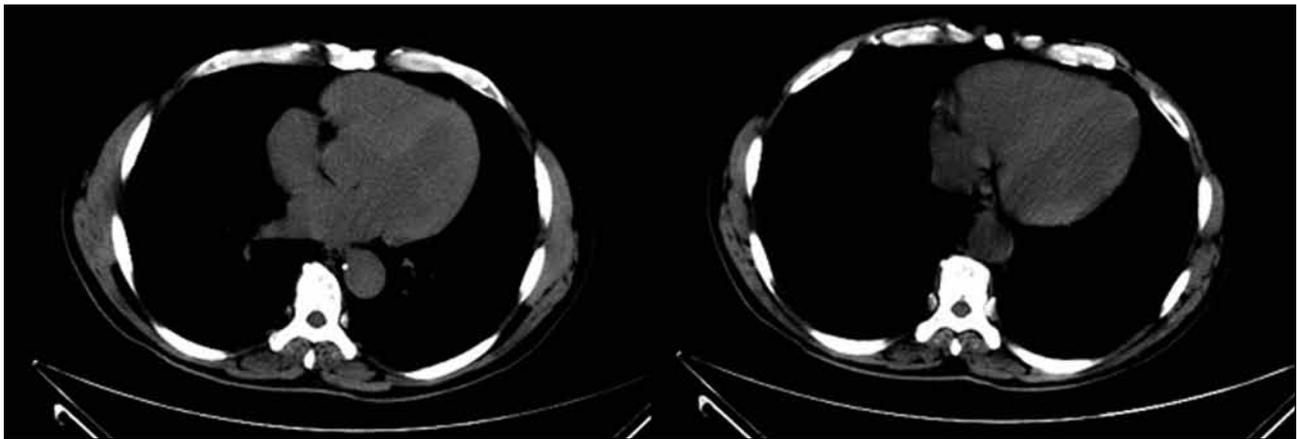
Preoperative non-contrast computed tomography 6 weeks previously: axial slices through the left ventricle of the heart showing that the calcification of the left ventricle was absent at that time.
